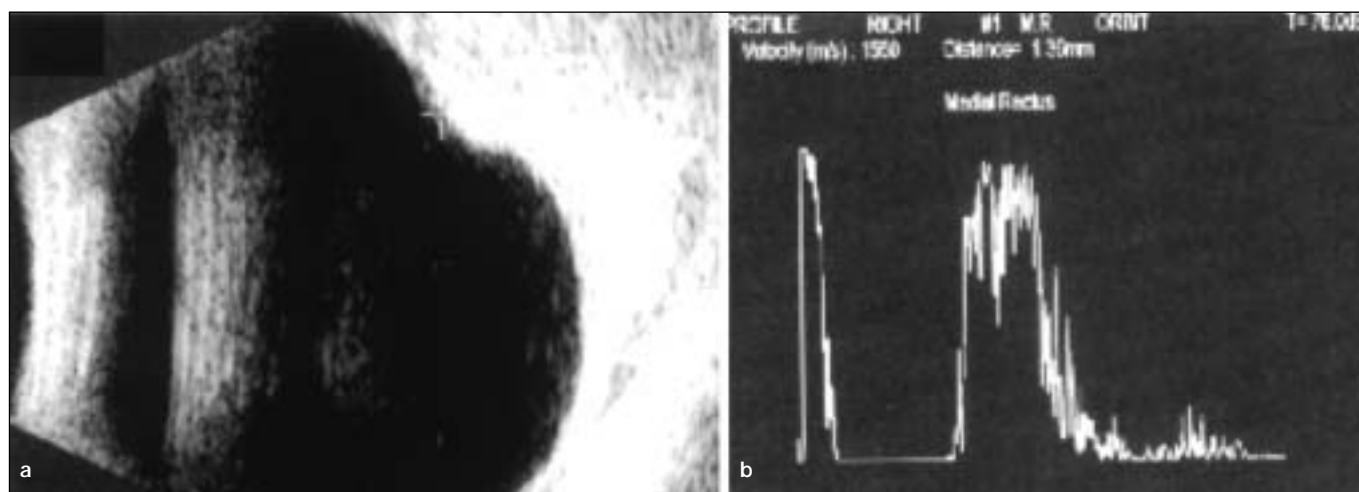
Ultrasonography shows a 1-mm-high lesion a) with high internal reflectivity b).
